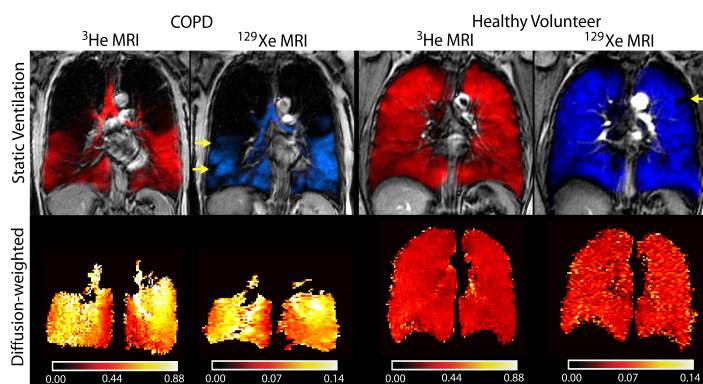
³He and ¹²⁹Xe MRI Static Ventilation Images and ADC maps
